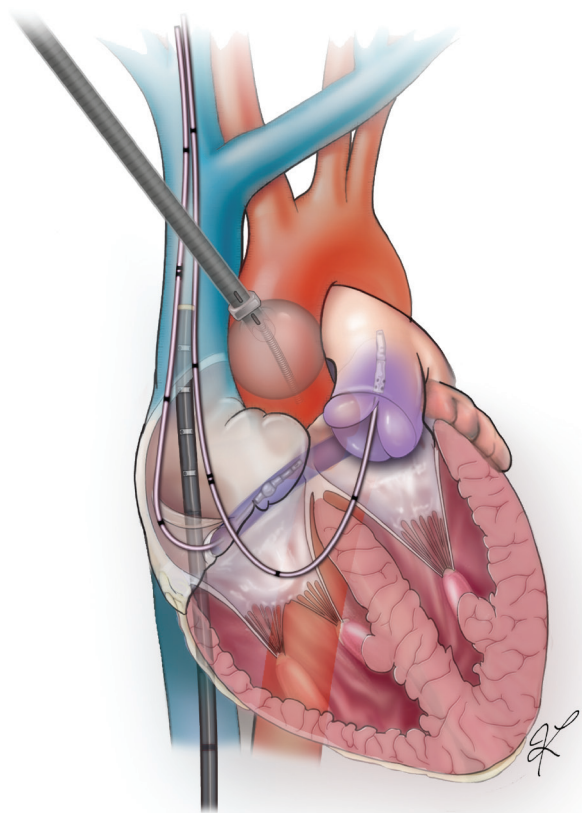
■ Transthoracic aortic cross-clamp and direct antegrade cardioplegia catheter.
